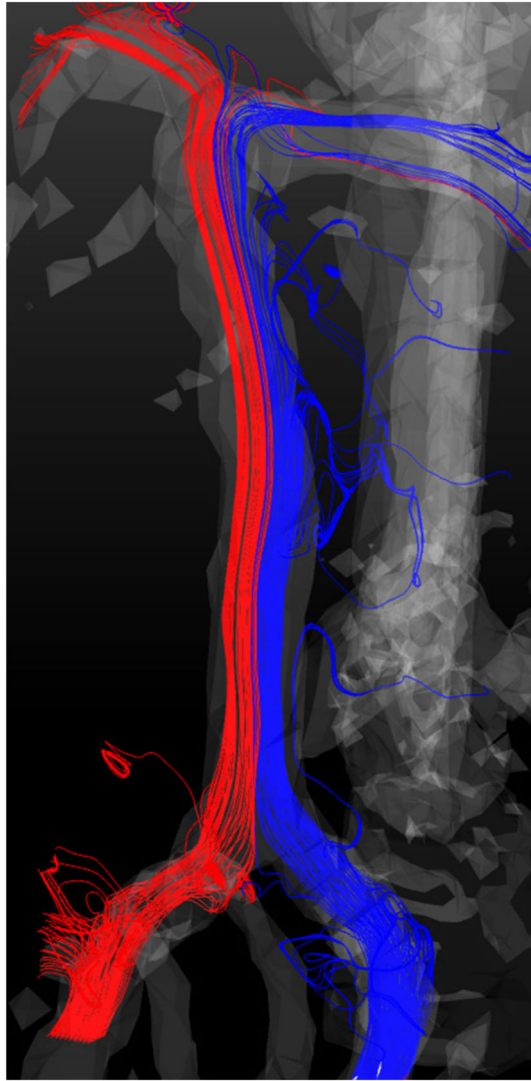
Flow streamlines in a healthy basilar artery measured with 4D Flow MRI. The streamlines are colored by the originating vertebral artery.
